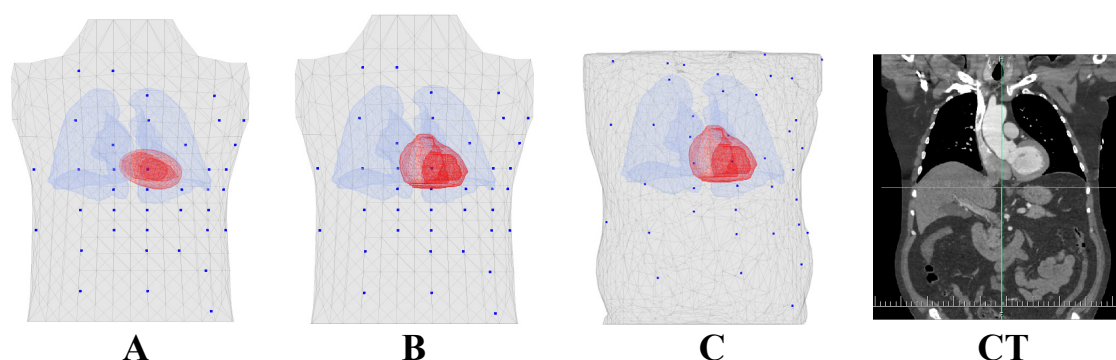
Torso models and CT scan of patient P1. Three models of torso, lungs and heart described in the text were used in the inverse computations. Dots mark positions of anterior electrodes.
